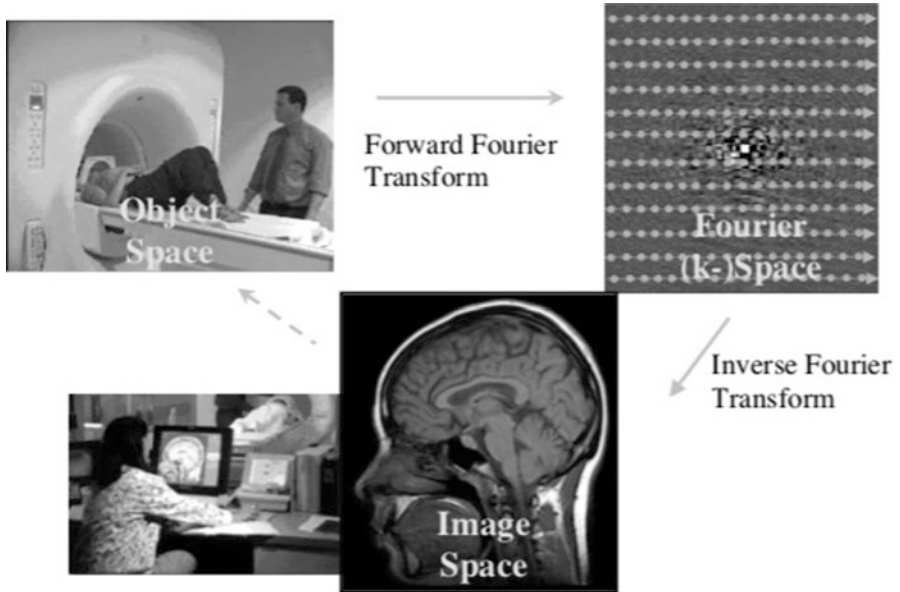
Brain MR image reconstruction process (Zhu 2003)
